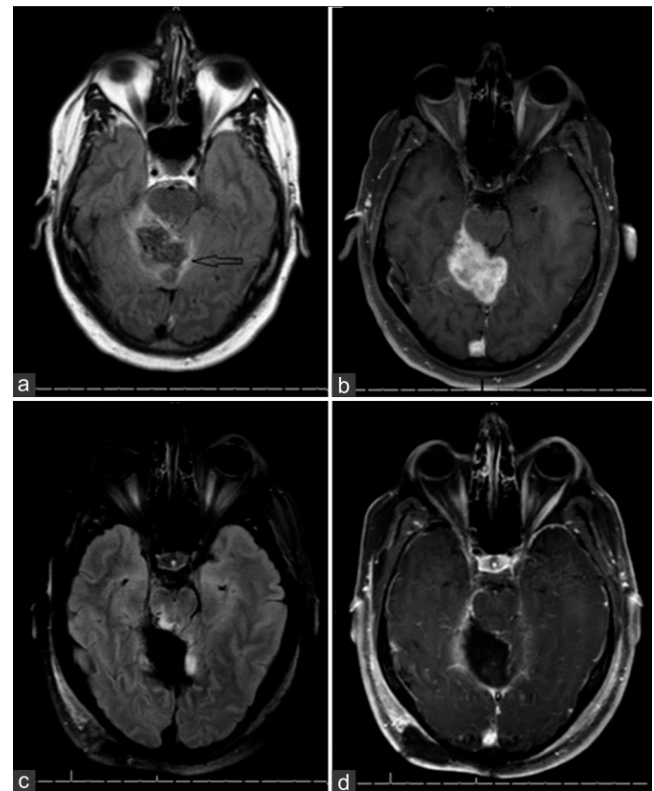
Axial magnetic resonance imaging images of fluid-attenuated inversion recovery (a) and T1 postcontrast (b) at initial presentation and then postoperatively (c and d) revealing complete radiographic resection of the lesion
